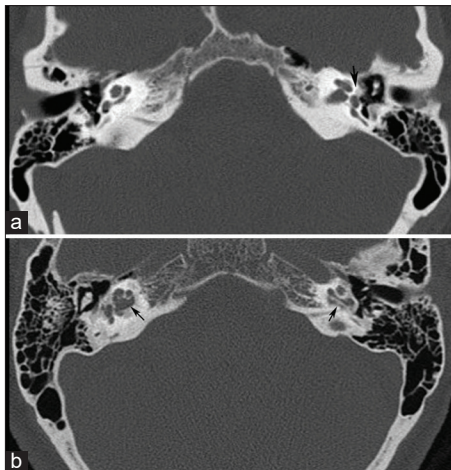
A 66-year-old man with otospongiosis. (a) Axial high-resolution computed tomography (HRCT) image demonstrates a small focus of decreased bone density in the region of the left fissula ante fenestram (arrow), consistent with fenestral otospongiosis (b) axial HRCT image in another patient with retro fenestral otospongiosis demonstrates low attenuation regions around the cochlea bilaterally (arrows) known as the “double ring sign.”
